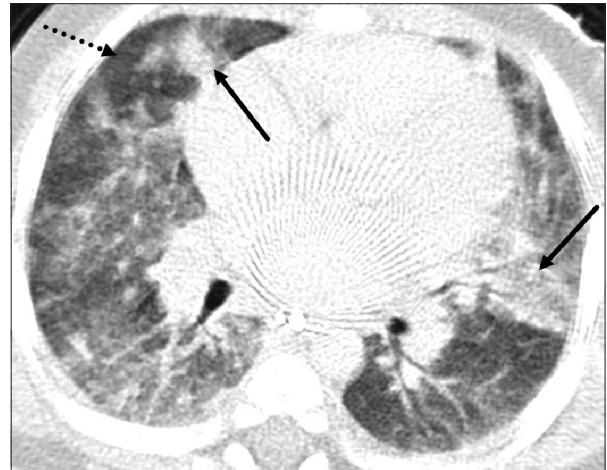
Axial chest computed tomography image of a 10-month-old male infant with pneumocystis pneumonia shows mid-lung predominant patchy airspace opacities (black arrows) with relative subpleural sparing (dashed black arrows)
